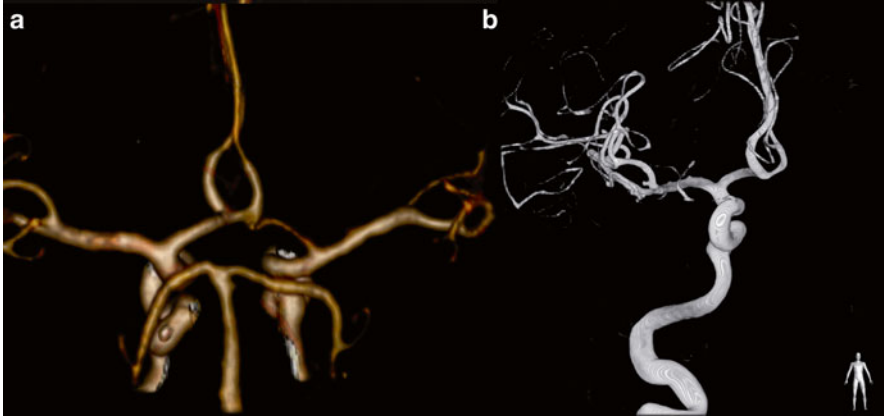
Fifty-six y/o female presented with subarachnoid hemorrhage. No aneurysms were found at CTA and DSA. CTA (a) demonstrates a hypoplastic left A1 segment, the Acom is demonstrated, suggesting that the left A2 is (partially) supplied via the Acom. DSA (b) demonstrates filling of the left A2 segment after contrast administration of the right carotid artery
